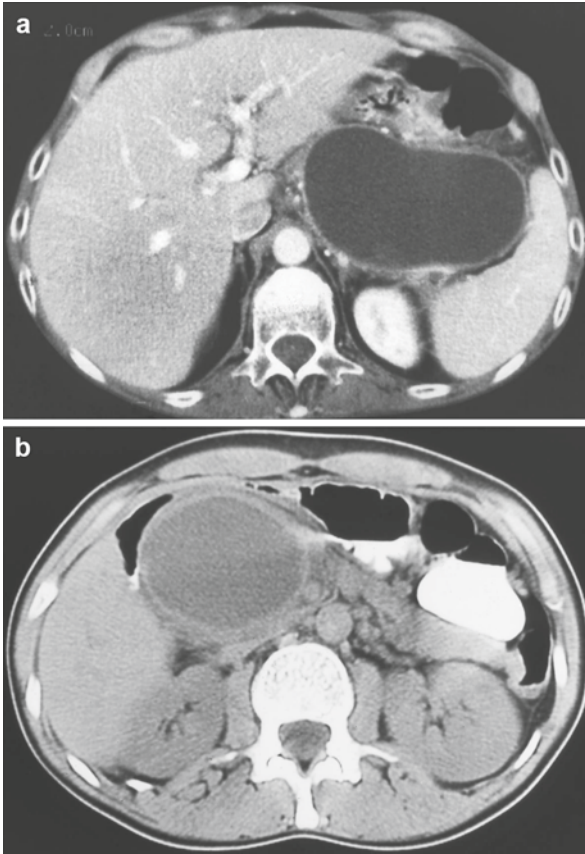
(a) Computed tomography revealing a pseudocyst closely adherent to the posterior wall of the stomach suitable for cyst-gastrostomy drainage. (b) Computed tomography revealing a pseudocyst arising from the head of the pancreas in close apposition to the duodenum suitable for transduodenal drainage into the duodenum
